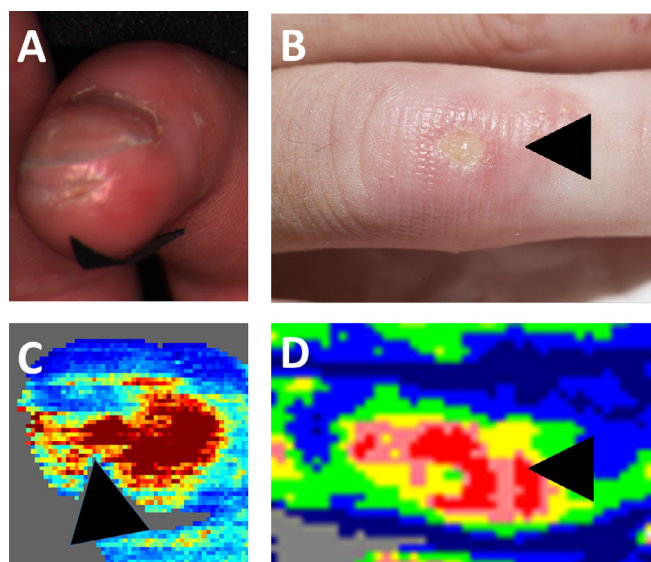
Imaging DUs in SSc. Images A & B are clinical images of a fingertip (A) and extensor (B) DU. Corresponding laser Doppler images are presented in C & D, respectively, depicting reduced perfusion to the centre of both types of DU compared to the surrounding tissue. In all the images, the position of the DU is indicated by a black triangle.
